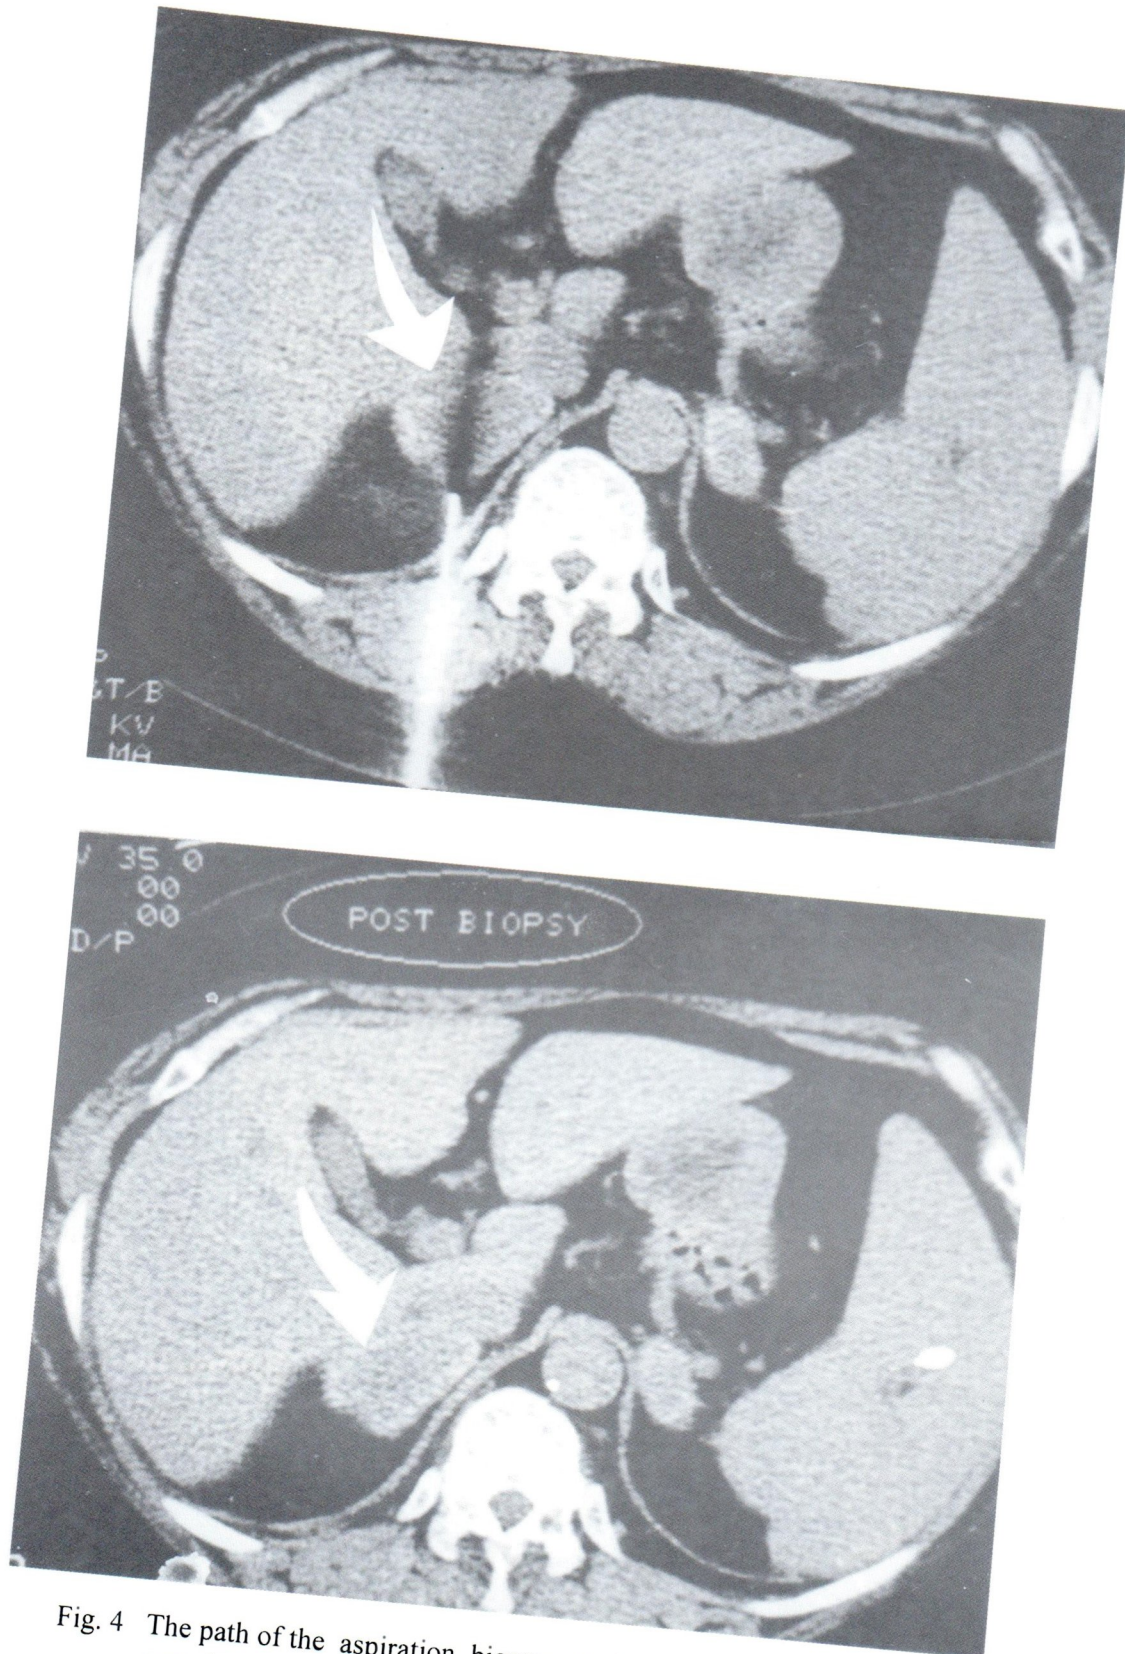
The path of the aspiration biopsy needle under CT localization was shown with the patient in prone position. There was no significant changes of the appearance of the mass post biopsy.
